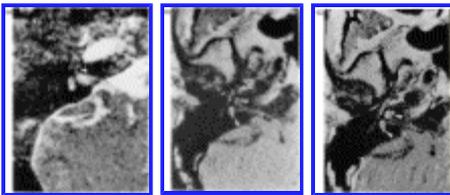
Active fibrosis. Patient referred 6 months after a bacterial meningitis. Incomplete bilateral cochlear ossification depicted by HRCT. Comparison of pre- (a) and post (b) Gd T1WI displays a labyrinthine enhancement. Abnormal spontaneous high signal intensity on T1WI of the membranous labyrinthine fluid (arrowheads). (c) T2WI a complete loss of the normal high signal intensity of the membranous fluid of the cochlea (arrowhead).
